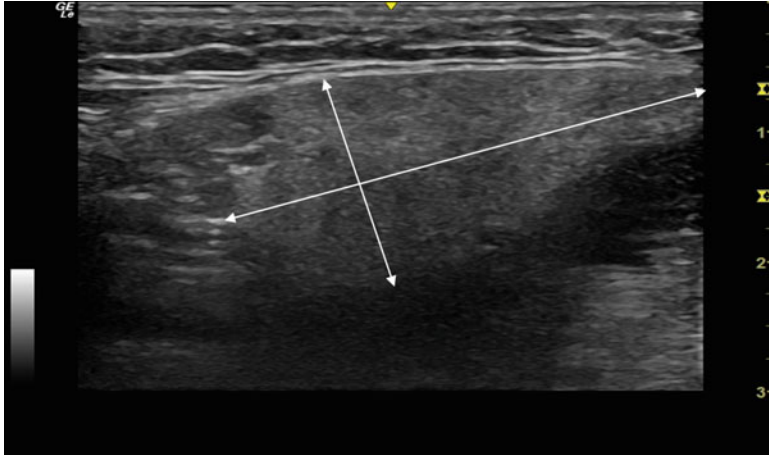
This is a transcutaneous ultrasound of a normal submandibular salivary gland. It has a homogeneous echogenicity (all the same color). For this view, the ultrasound probe is placed just below the body of the mandible
